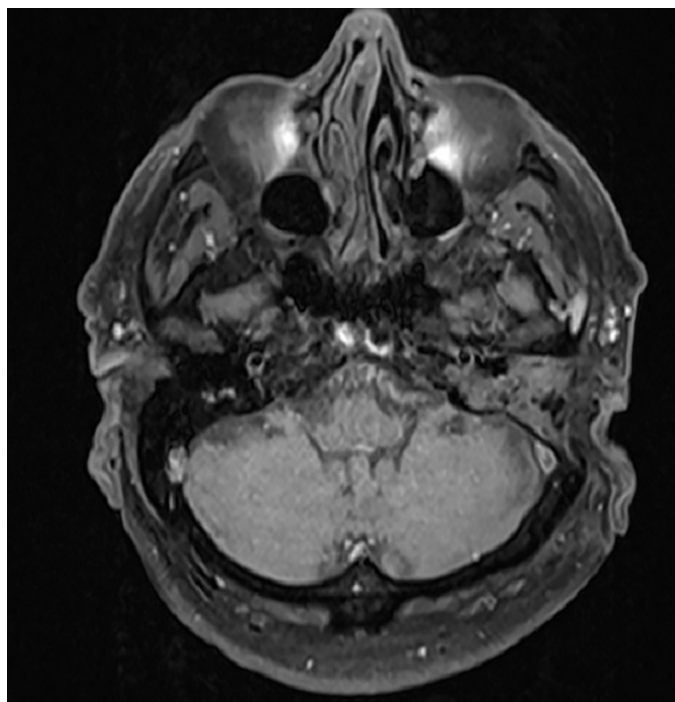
Axial T1 MR image showing an increased signal intensity of the postoperative area, corresponding to postoperative fibrosis, without contrast imbibition.
